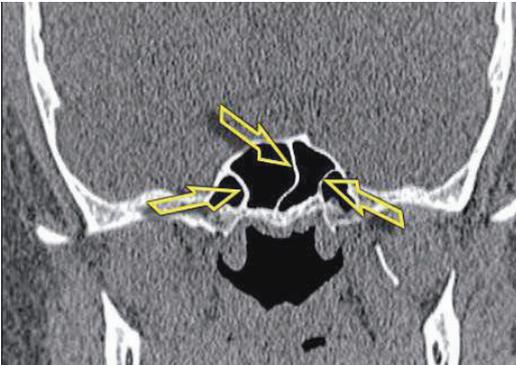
CT scan of the paranasal sinuses, frontal plane. Total number of septa — 3, total number of antra in the sphenoid sinuses — 4 (3/4).
